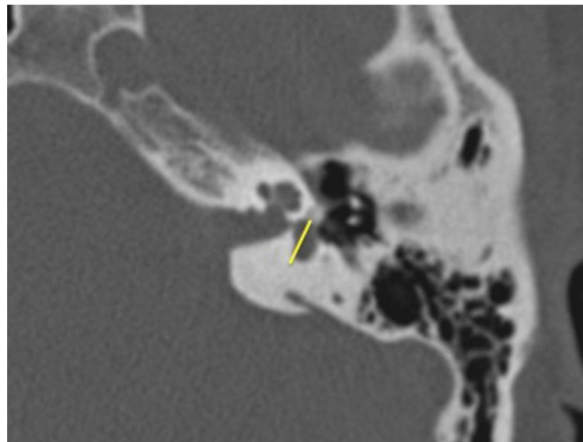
9): Axial CT image of Fenestral otosclerosis .shows otosclerosis of Fissula ante fenestram and oval window .
